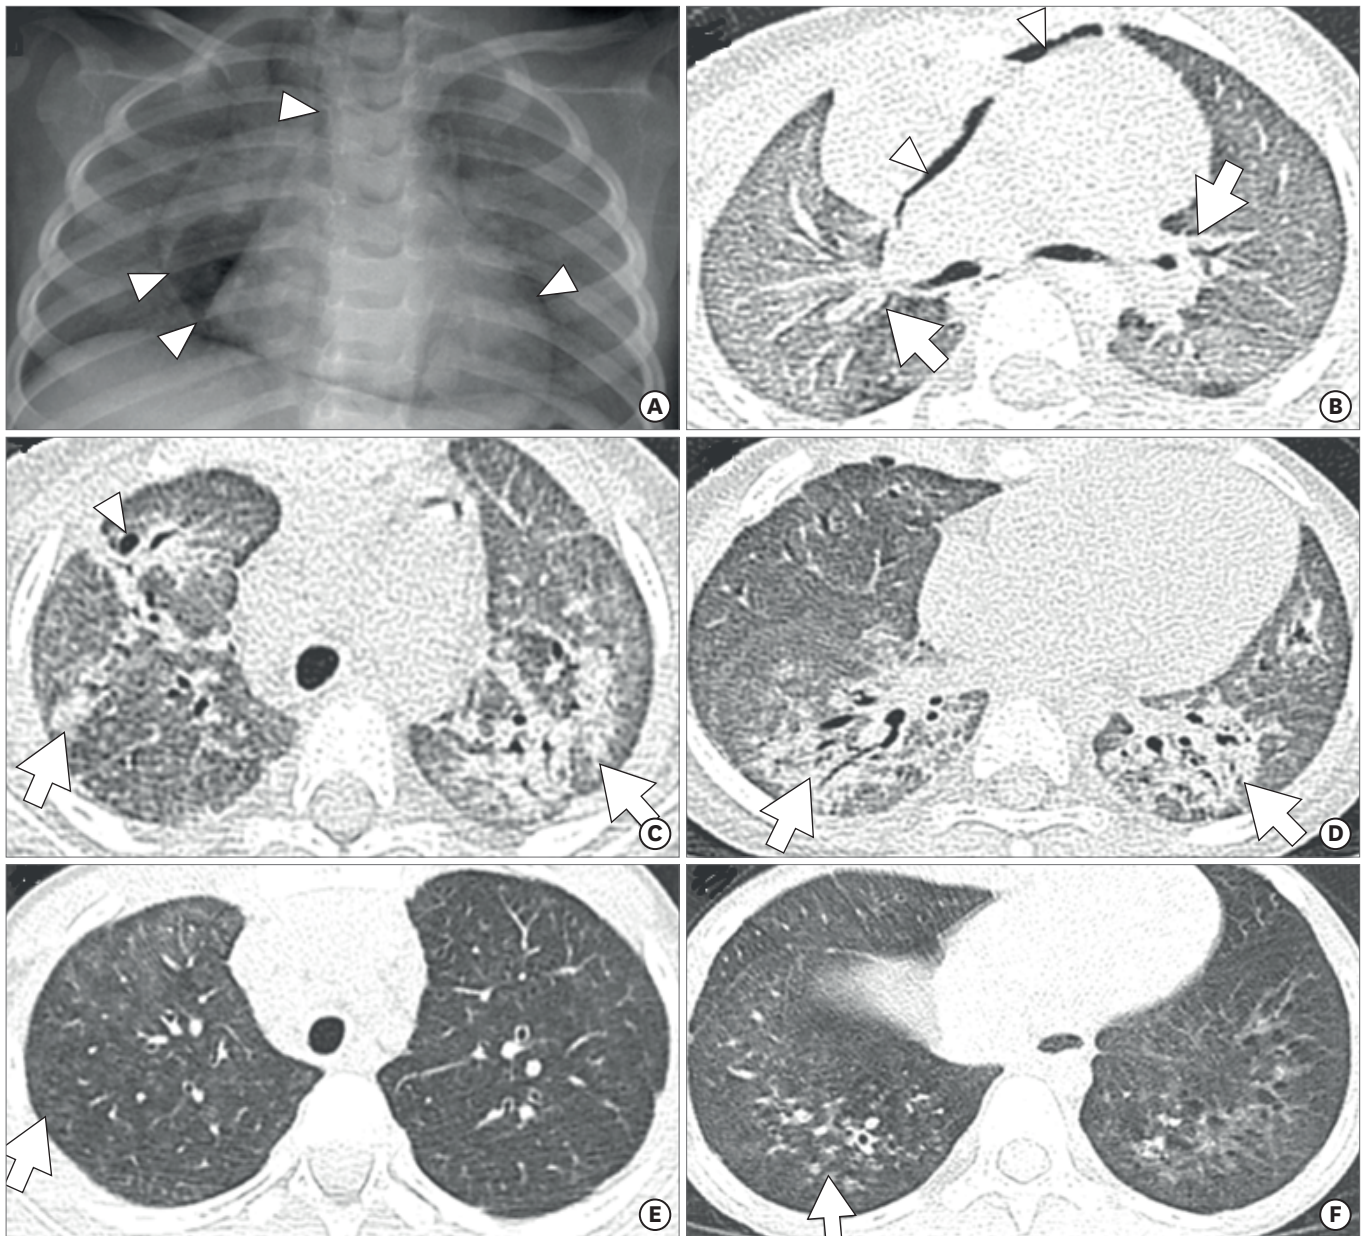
Chest radiography and computed tomography (CT) of case 2. At 12 months of age, (A) initial chest radiography and (B) a 1-mm-thick axial CT image revealed diffuse ground-glass opacities and suspicious pulmonary interstitial emphysema (arrows) in both lungs and pneumomediastinum (arrowheads). (C, D) After 2 months, diffuse ground-glass opacities and patchy consolidations (arrows) along the bronchovascular bundles were noted, and several air cysts are visible (arrowhead). (E, F) After 5 years, subtle ground-glass opacities and multiple tiny ill-defined centrilobular nodules (arrows) were still evident in both lungs.
